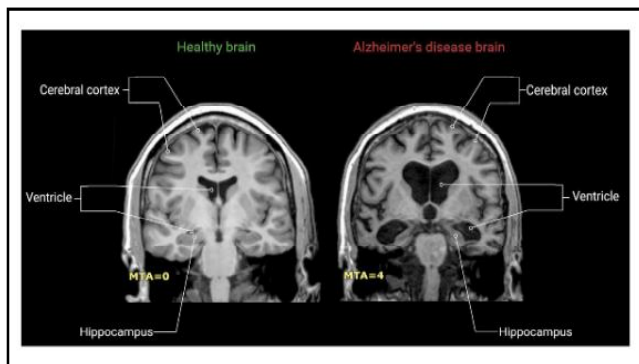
MRI scan of a healthy brain and Alzheimer's brain.
